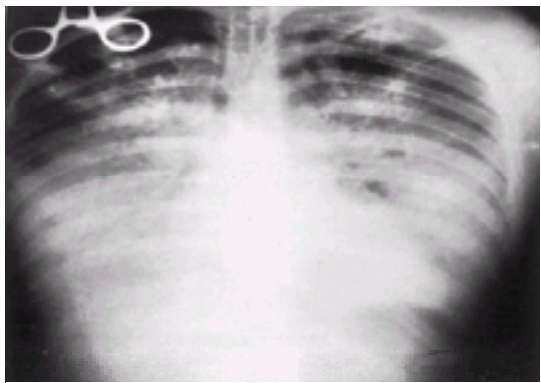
Plain chest radiograph in a patient with adult respiratory distress syndrome.
